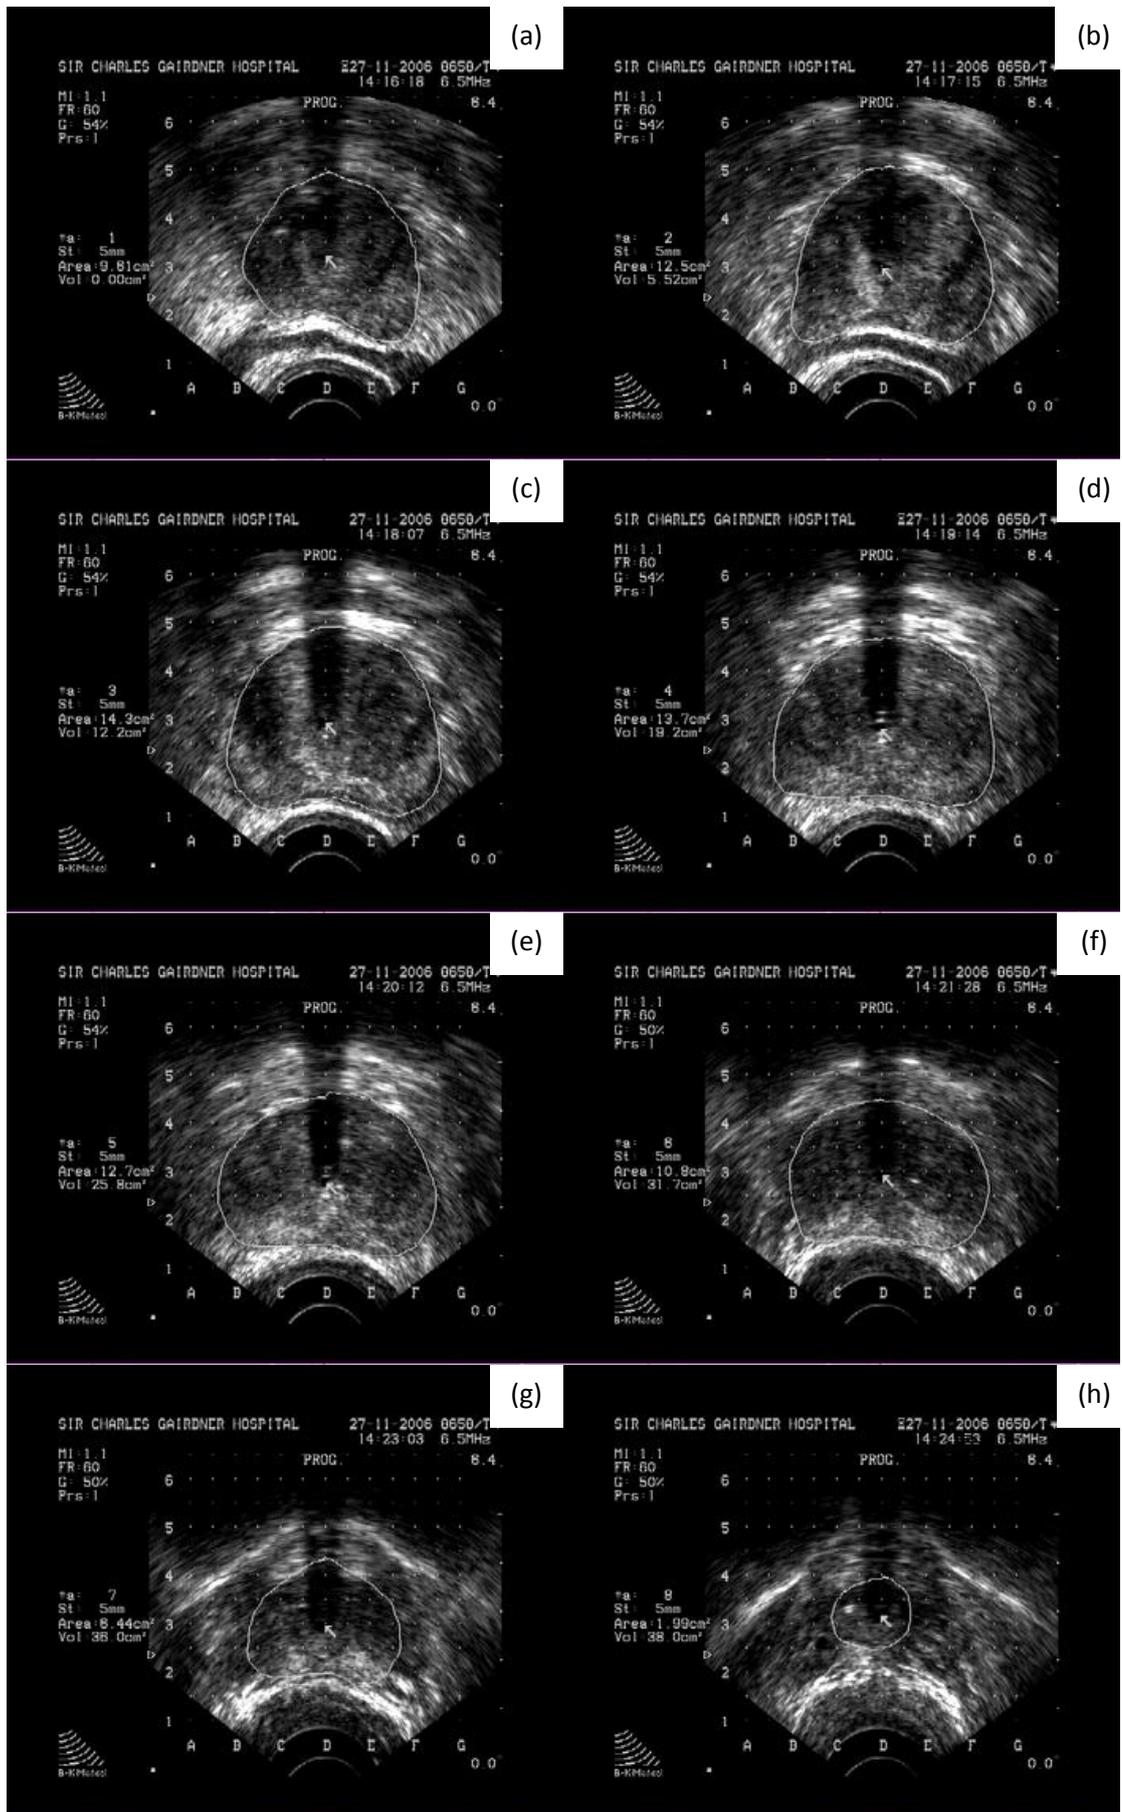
Ultrasound volume study from prostate base (a) to apex (h).
